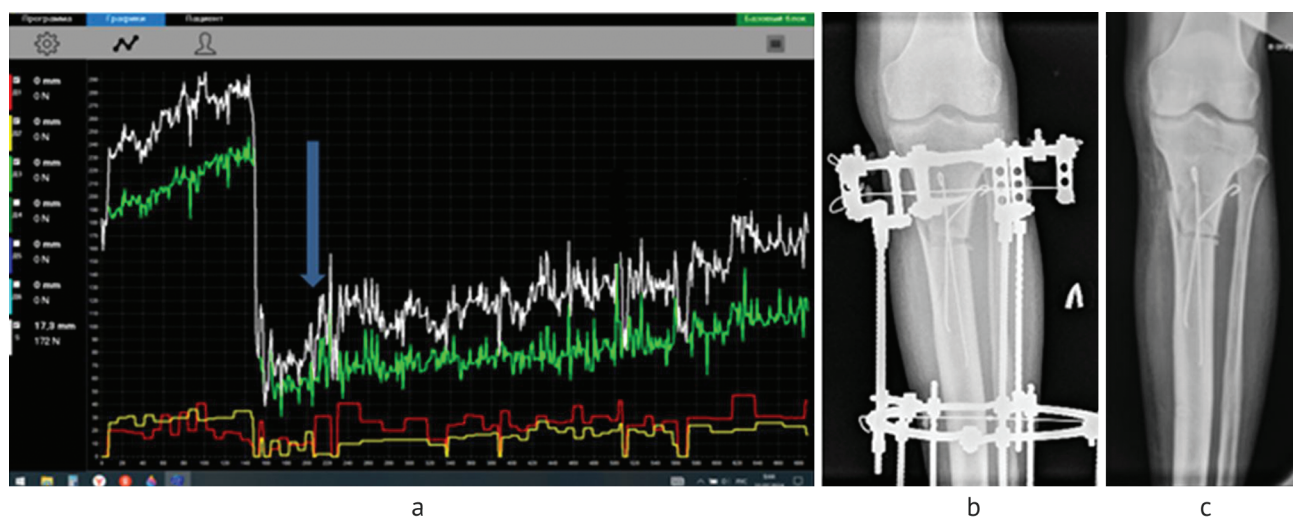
Dynamics of distraction forces recorded on 31.07.24: the arrow indicates the re-start of lengthening along the leading rod (a); control radiograph of the left tibia on the day of accomplished distraction period (b) and on the day the external fixation device was removed (c)
